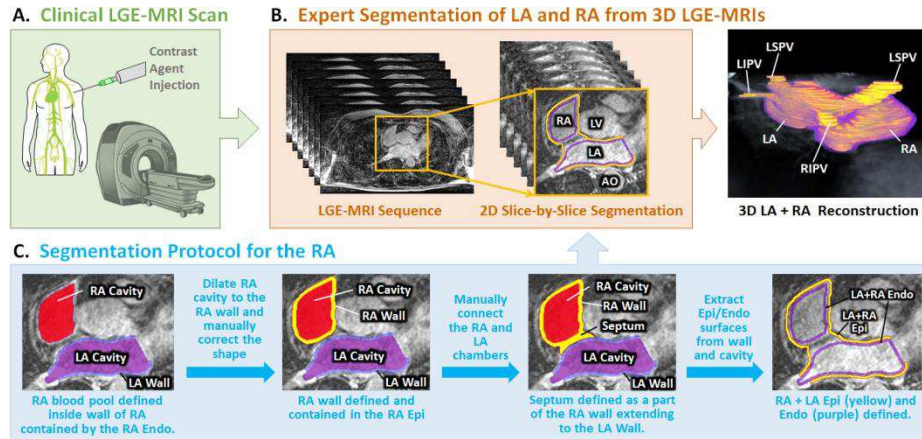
Data acquisition and the protocol for labelling the left atrial (LA) and right atrial (RA) epicardium (Epi) and endocardium (Endo) from late gadolinium-enhanced magnetic resonance imaging (LGE-MRI). A) Clinical MRI scanners were used to acquire LGE-MRIs. B) The LGE-MRIs were manually segmented in a slice-by-slice manner by experts to obtain labels of the LA/RA epicardium and LA/RA endocardium. C) RA manual annotation based on the LA annotation protocol provided by University of Utah [4]. AO, aorta; LV, left ventricle; PV, pulmonary vein; LS/LIPV, left superior/inferior PV; RS/RIPV, right superior/inferior PV.
